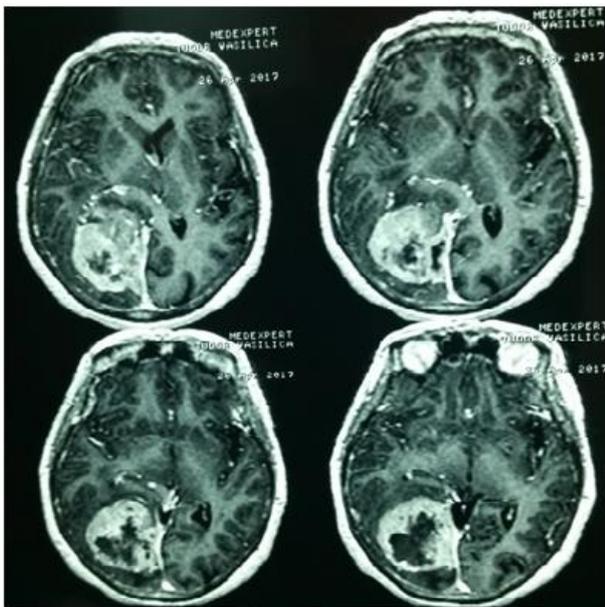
Preoperative enhanced CT- scan images, axial view
